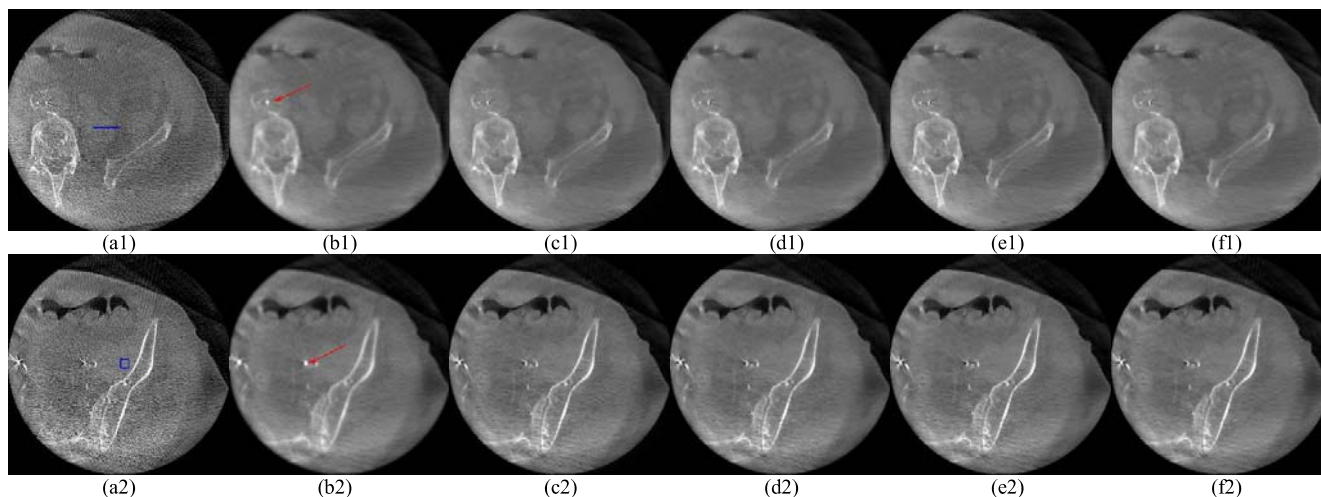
CBCT slices of the abdominal vasculature: (a1) slice 169 of CBCT; (b1)-(f1) filtered CBCT slice obtained by PWLS algorithms with isotropic penalty, TV penalty, Huber penalty, anisotropic penalty and the proposed edge-preserving penalty, respectively. (a2) slice 19 of CBCT; (b2)-(f2) filtered CBCT slice obtained by PWLS algorithms with isotropic penalty, TV penalty, Huber penalty, anisotropic penalty and the proposed edge-preserving penalty, respectively. Display window: [-1024 HU, 1976 HU].
